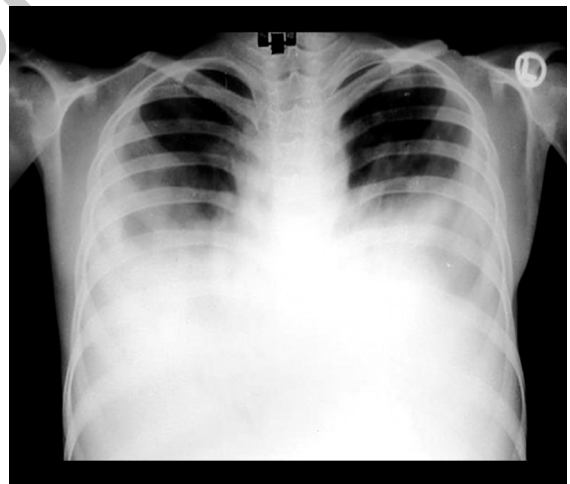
X-ray findings—large volumes of complete “white out” on the affected side completely obscuring the hemi-diaphragm. With small-volume effusion, only partial “white-out” on the affected side is seen, with only partial obstruction of the hemi-diaphragm.
